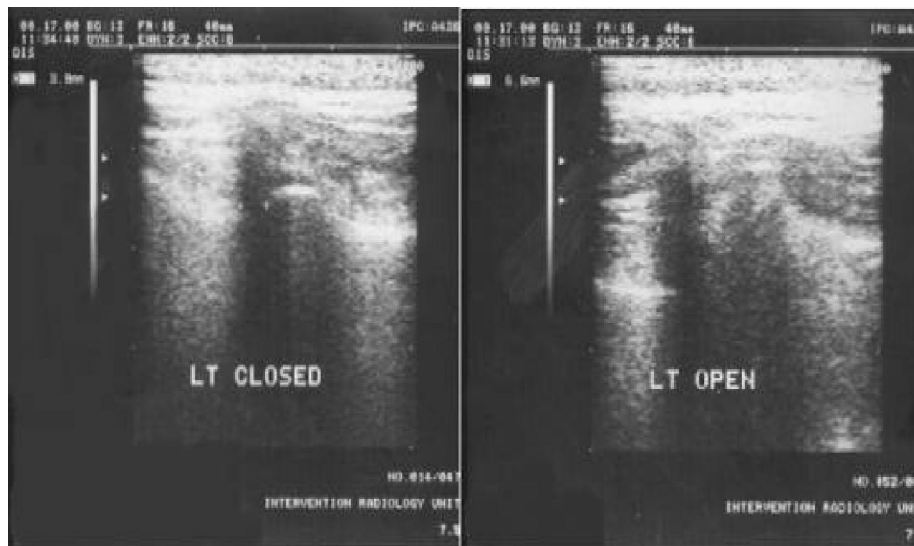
Sonographic scanning showing normal distance between the condyle and the glenoid fossa (3.9 mm), *left* closed mouth position, *right* opened mouth position.
